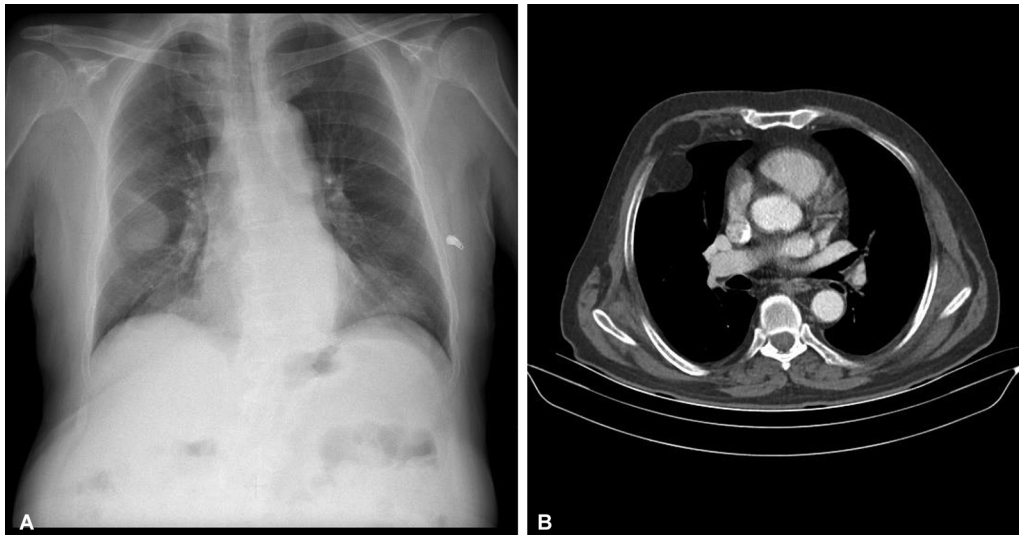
(A) Chest X-ray posteroanterior (PA) image showing an opacity in the right midzone of the hemithorax. (B) Noncontrast-enhanced axial computed tomography (CT) image shows the inverted soft tissue intercostal herniation through the fourth intercostal space.
